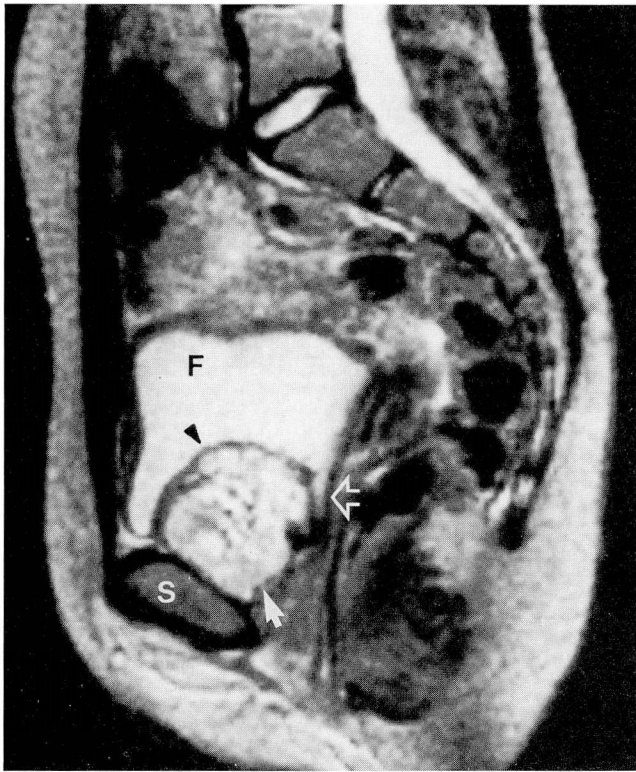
Sagittal T2-weighted (TR 2000 msec, TE 90 msec) MR image of the pelvis, through the center of the mass. Fluid in the bladder is visible (F). No contrast has been given. The mass (white arrow) is inferior to the bladder, closely applied to the symphysis pubis (S). The bladder wall (black arrowhead) is seen as a thin dark line lifted by the mass. A portion of the bladder neck (open arrow) is seen posterior to mass. The mass does not appear to enter the lumen of the bladder. The bright signal intensity of the mass is nonspecific, although consistent with pheochromocytoma.
